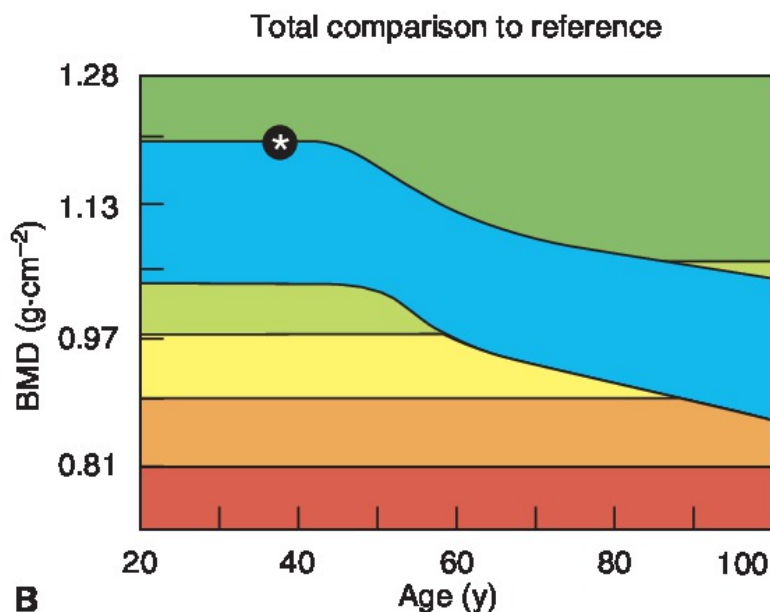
Dual-Energy X-Ray Absorptiometer.
